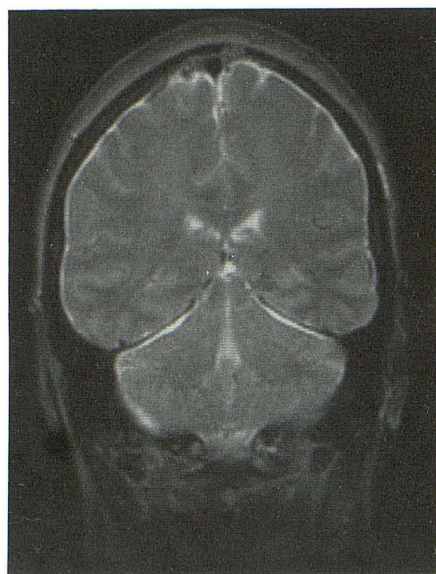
Coronal T2-weighted (2000/100) MR image shows diffuse meningeal abnormal signal throughout calvarium, including the tentorium.
